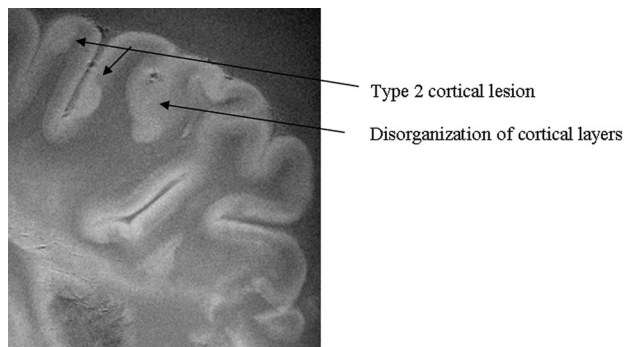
SE diffusion T2-weighted image, TR = 1000 ms, TE = 65 ms, FOV = 15 cm, matrix = 512 × 512, and thickness = 1 mm. Type 2 cortical lesions. These cortical lesions involve all layers of the cortex, and the normal trilaminar appearance is lost. The subcortical white matter is unaffected. Disorganization of the cortical layers is the hallmark of this pattern.
